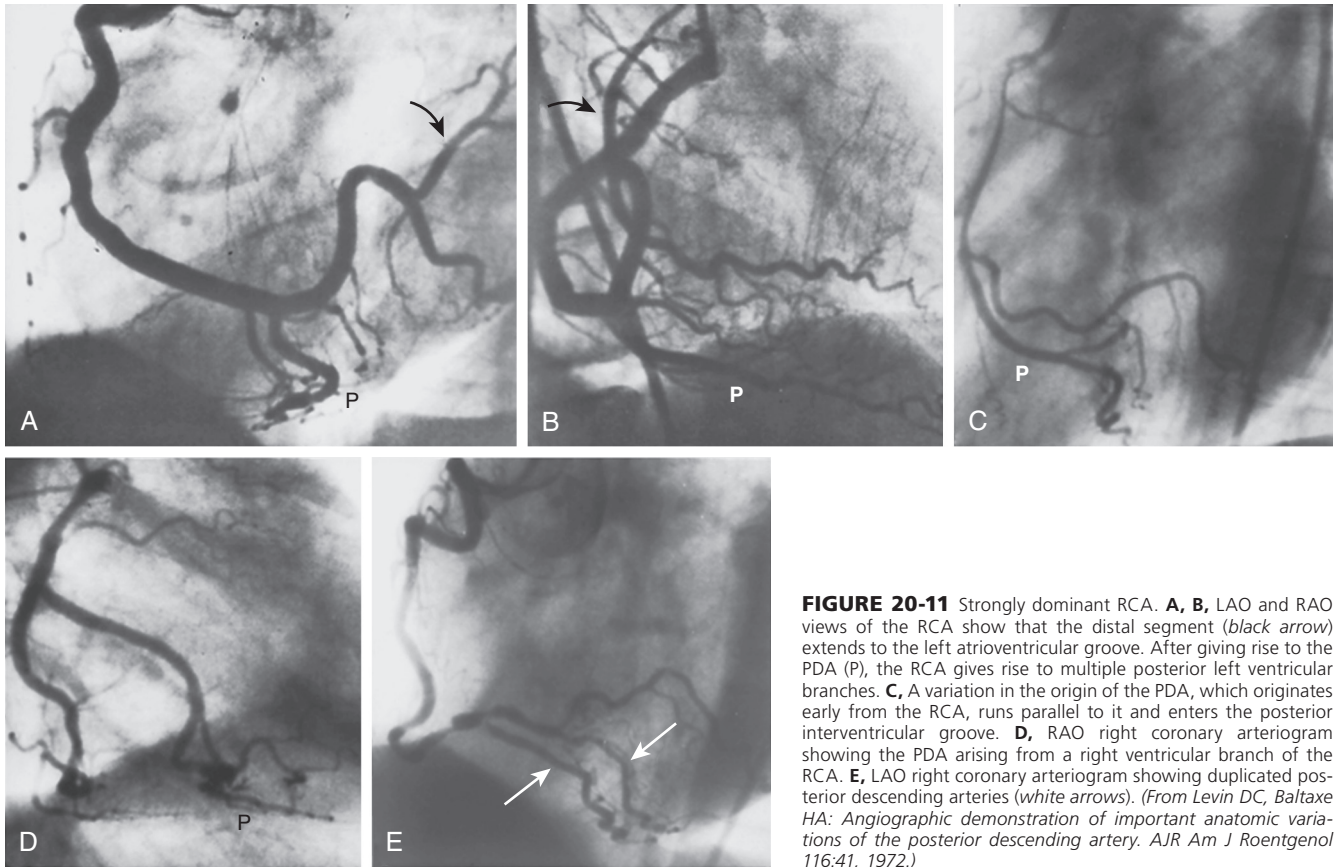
Strongly dominant RCA. A, B, LAO and RAO views of the RCA show that the distal segment (black arrow) extends to the left atrioventricular groove. After giving rise to the PDA (P), the RCA gives rise to multiple posterior left ventricular branches. C, A variation in the origin of the PDA, which originates early from the RCA, runs parallel to it and enters the posterior interventricular groove. D, RAO right coronary arteriogram showing the PDA arising from a right ventricular branch of the RCA. E, LAO right coronary arteriogram showing duplicated posterior descending arteries (white arrows). (From Levin DC, Baltaxe HA: Angiographic demonstration of important anatomic variations of the posterior descending artery. *AJR Am J Roentgenol* 116:41, 1972.)
